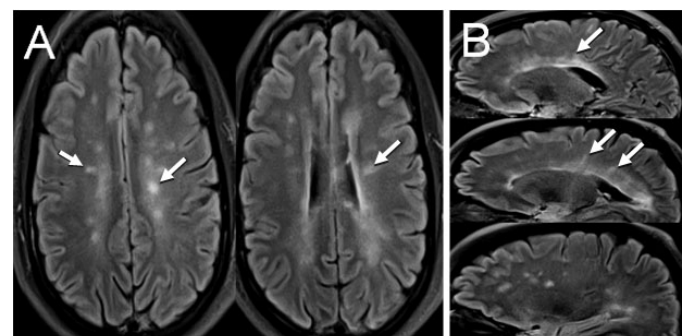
(A) Brain MRI axial images of T2/FLAIR sequence demonstrating several hyperintense lesions in the periventricular and subcortical white matter of bilateral frontal and parietal lobes. (B) Brain MRI sagittal images of T2/FLAIR sequence demonstrating several demyelination plaques in the corpus callosum (Dawson's fingers, see arrows), bilateral cingulate gyri as well as in the subcortical white matter of bilateral frontal and parietal lobes.
